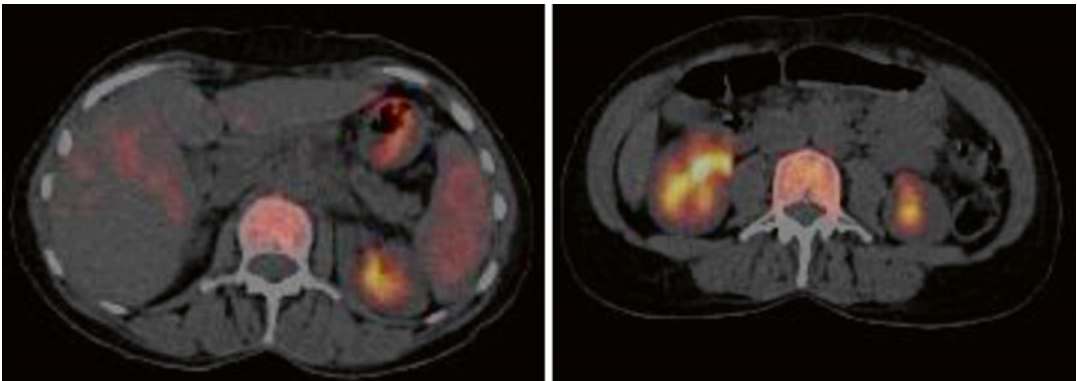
Fused PET/CT – interim: No enlarged lymph nodes or abnormal FDG uptake is noted in the abdomen
